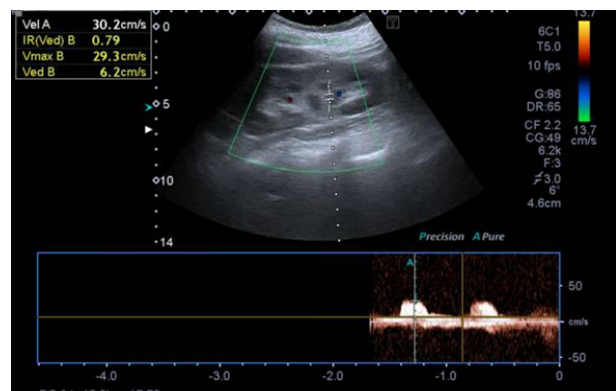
Renal Doppler ultrasound of the left kidney.
